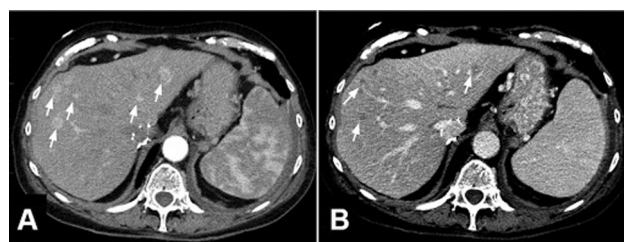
(A, B) Axial computed tomography of the abdomen with IV contrast 4 weeks after the metastasis detection demonstrates multiple arterially-enhancing lesions in both lobes of the liver with early venous washout, consistent with recurrent multifocal hepatocellular carcinoma (arrows).
